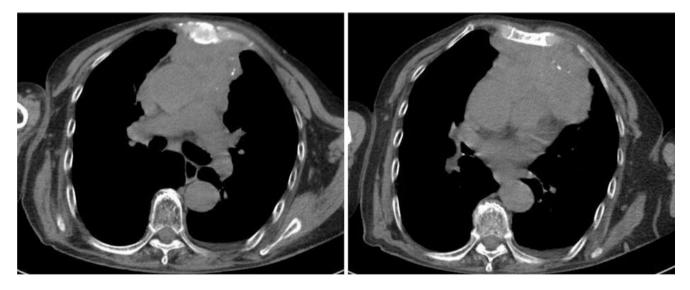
Chest CT images of a 78-year-old woman complained of cough for 5 months and left shoulder and back pain for half a month
